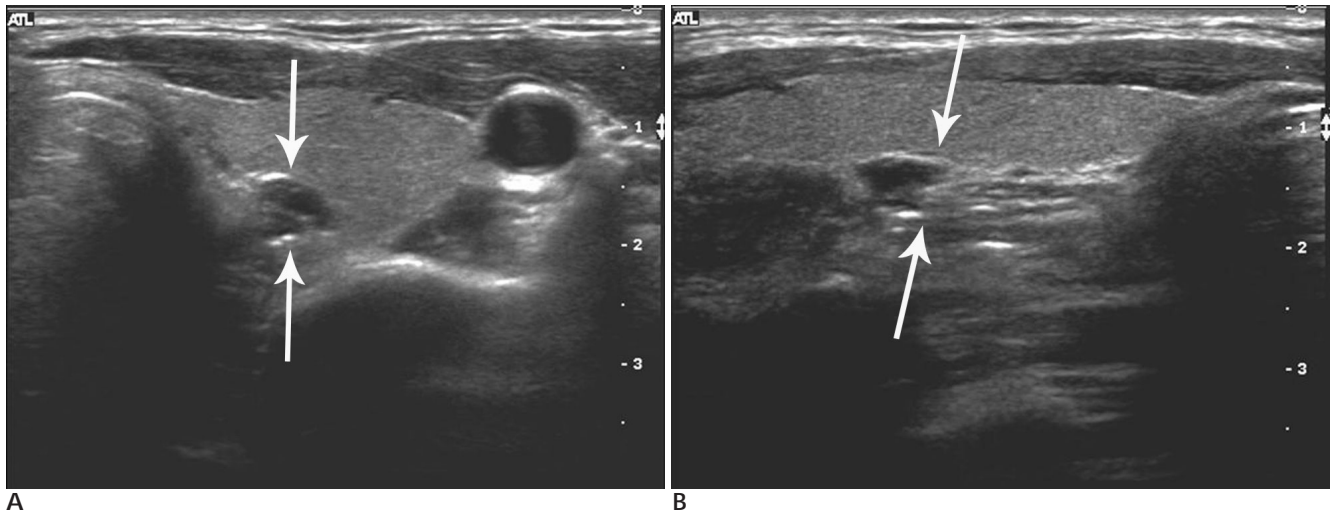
A 41-year-old man with an incidentally found hypoechoic nodule at the left thyroid during ultrasonography (US).
